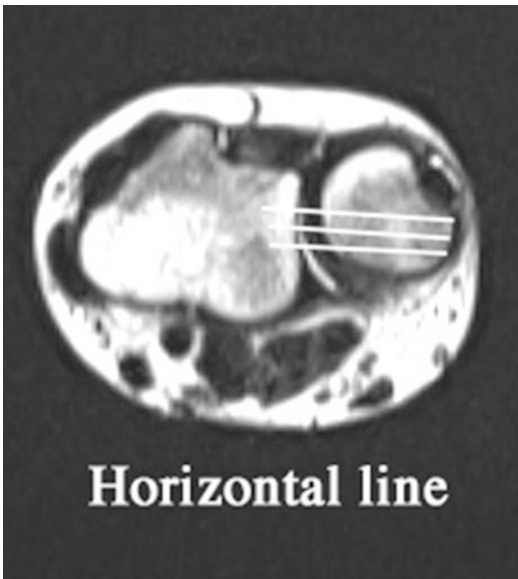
Magnetic resonance imaging scouted by the horizontal line
